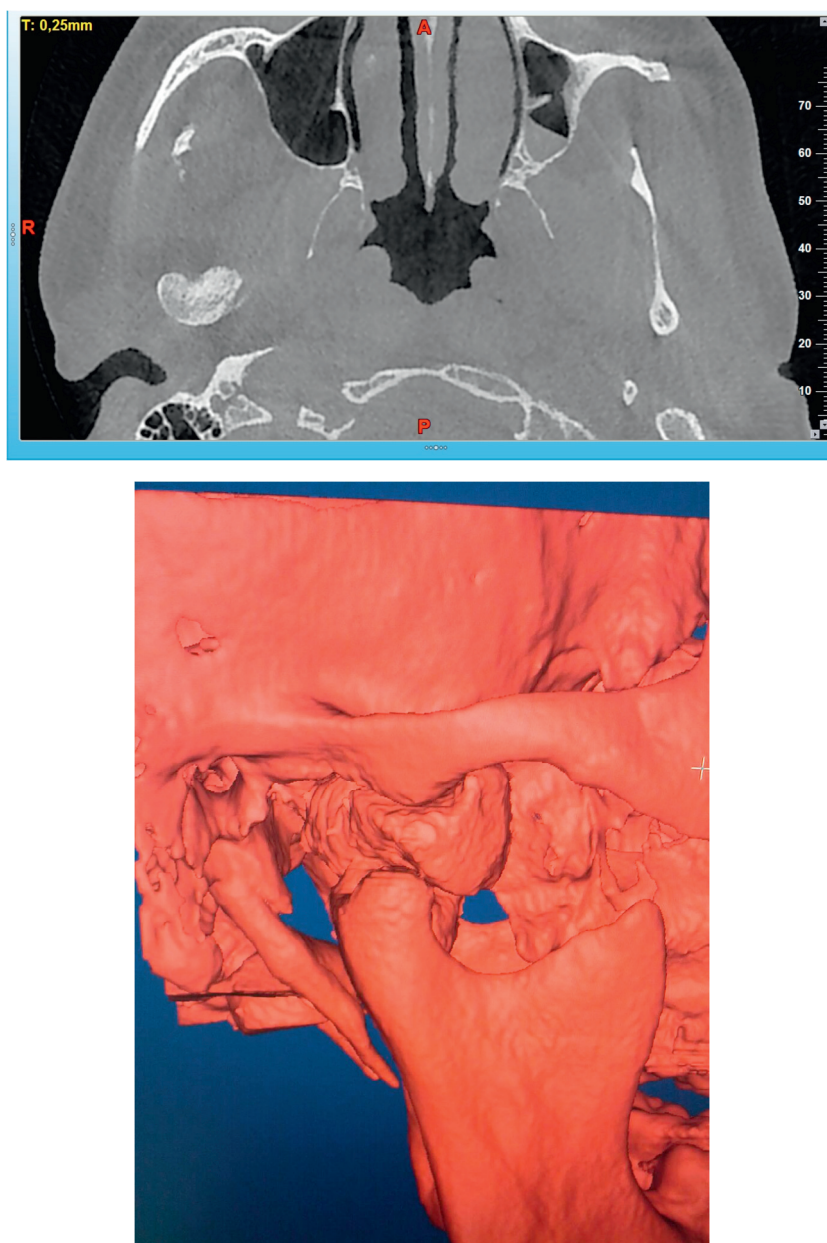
A: Preoperative Cone-beam computed tomography (CBCT) confirming bony expansion of the right condyle in axial section. B: CBCT 3D images demonstrate the well-defined margin of the radiopaque mass on the anteromedial and medial surface of the condylar neck.
